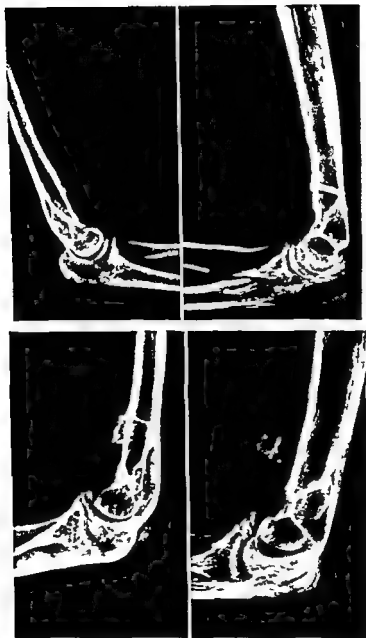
A series of roentgenograms of the state of the transposed medial epicondyle ad modum Steindler at follow-up. In the last example the epicondyle has broken loose from its attachment to the bone.
